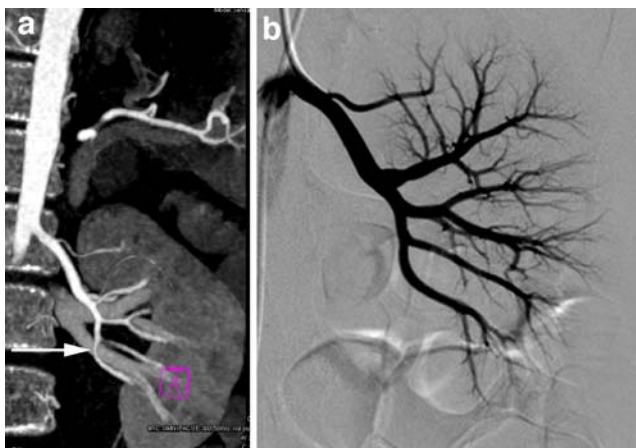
A 10-year-old girl with vasculitis. a 16-slice multidetector CTA was interpreted as showing stenosis of a lower pole branch of the left renal artery (arrow). b This was not confirmed at angiography
